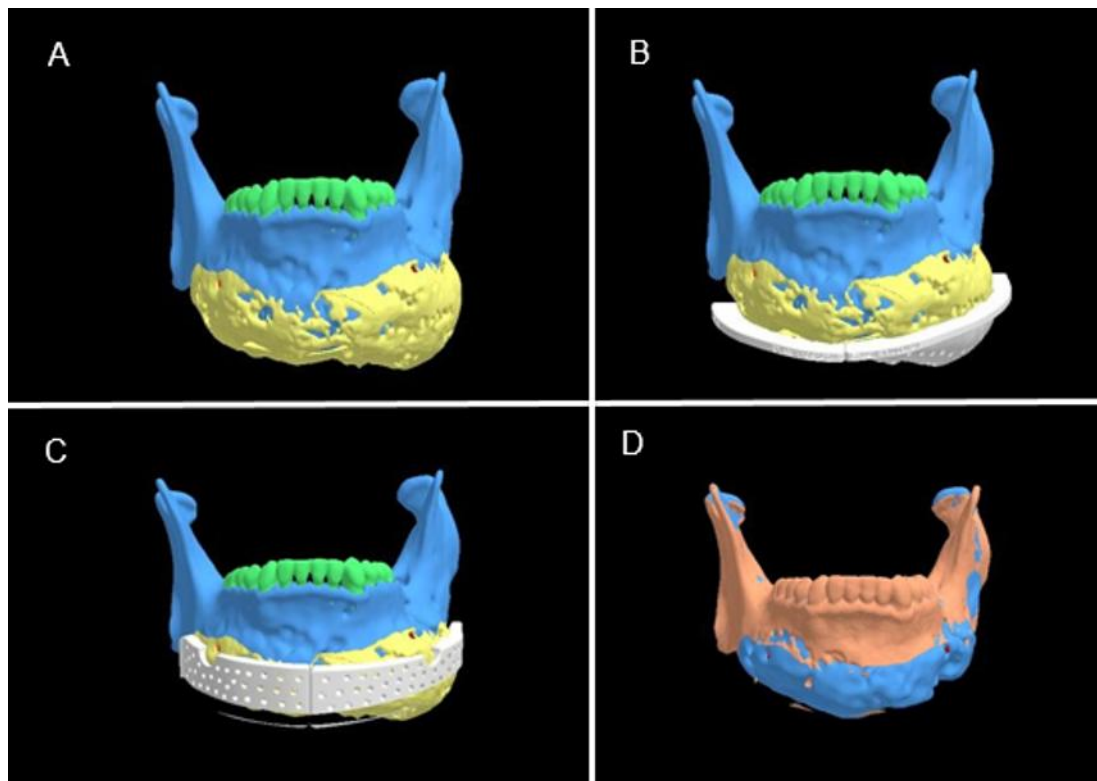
A) 3D reconstruction of the preoperative computed tomography scan. B) Surgical guide for axial osteotomies. C) Surgical guide for sagittal osteotomies. D) 3D reconstruction of the postoperative computed tomography scan superimposed on the virtual surgical plan.
